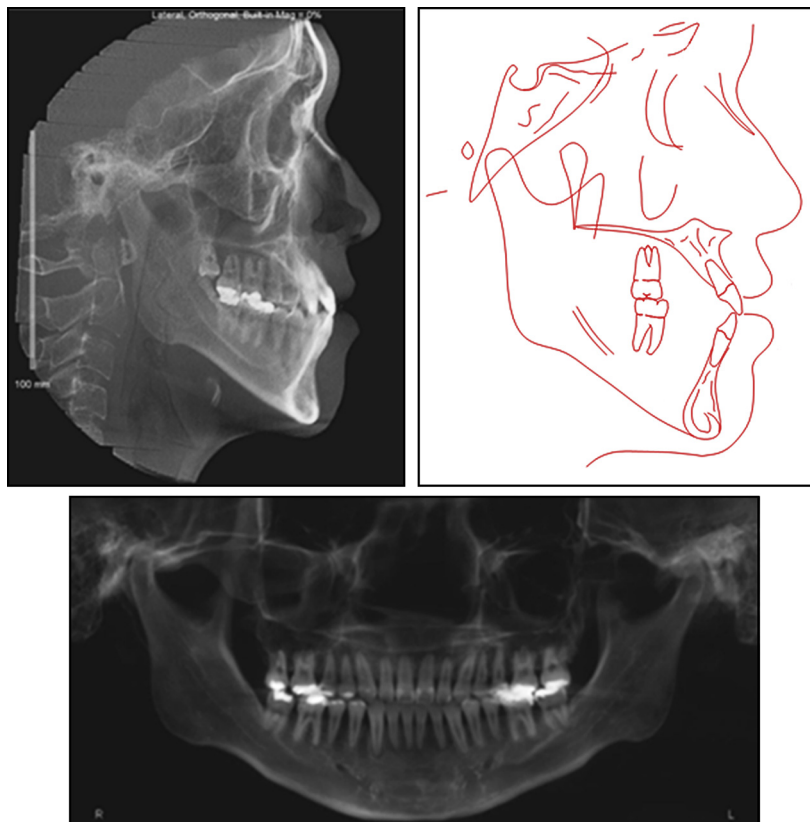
Final orthogonal lateral cephalometric radiograph, cephalometric tracing, and panoramic radiograph.
